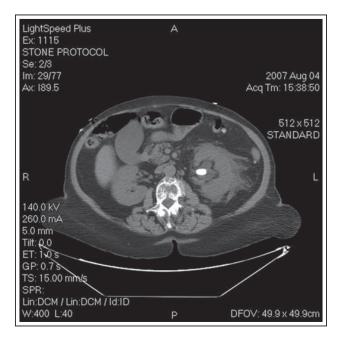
Axial computed tomography of the abdomen demonstrating the 12 mm left ureteropelvic junction stone with associated mild hydronephrosis and perinephric stranding.
